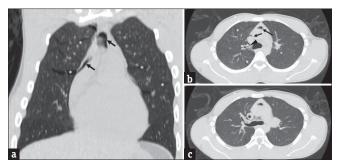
Coronal (a) reconstructed and axial (b and c) unenhanced CT images showing low attenuation areas along the bronchovascular sheaths (white and black asterisks) and the mediastinum (black arrows) due to mediastinal and interstitial emphysema
